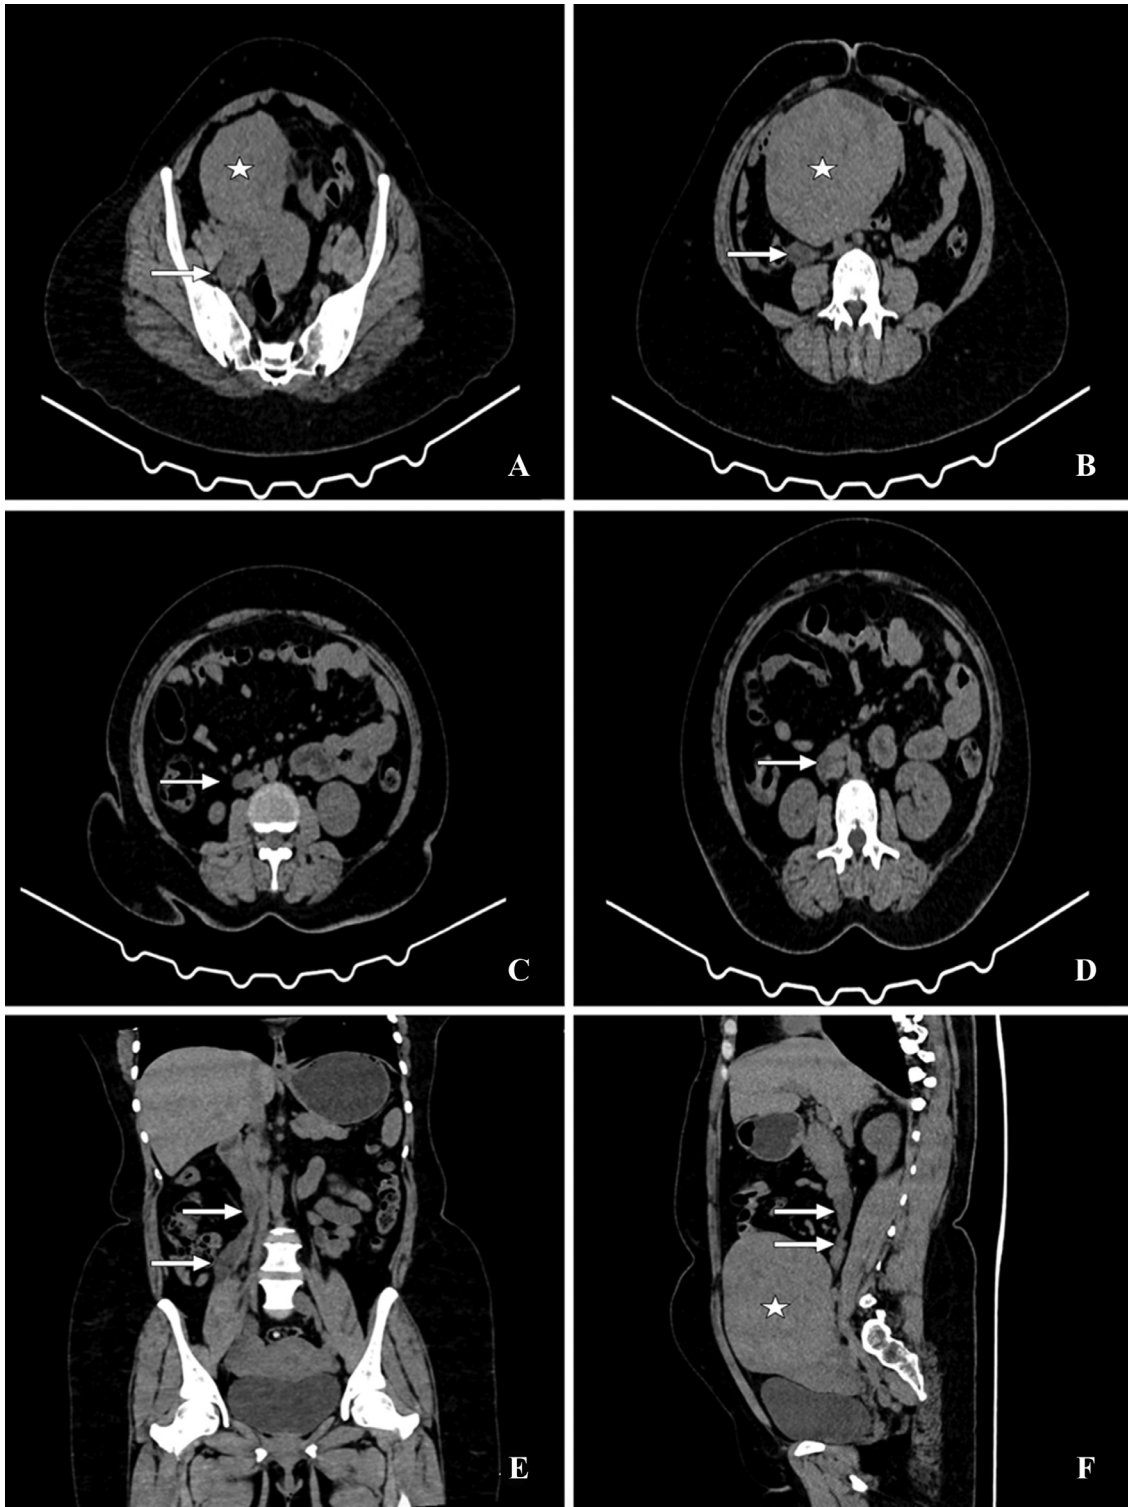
(A-F): A 40-year-old woman complained of lower abdominal pain, distension, and bloating that had been worse during the previous 6 months. Pre-operative Computed Tomography (CT) Abdomen (Plain): Multi-Planar Reformatted (MPR) images: (A, B, C, D - Axial, E - Coronal, F - Sagittal sections) show a bulky uterus with focal exophytic mild heterogeneous isodense to hypodense mass lesion (iso to myometrium) in the antero-superior wall myometrium of the uterus (fundus)—Sub-serosal fibroid uterus with necrotic degeneration (white asterisk). A focal multiloculated cystic lesion in the right adnexa (epicenter in the ovary) of serpiginous appearance extending superiorly along the para-caval region till the infra-renal segment of the pre-caval region—Ovarian lymphangioma (short white arrows).
